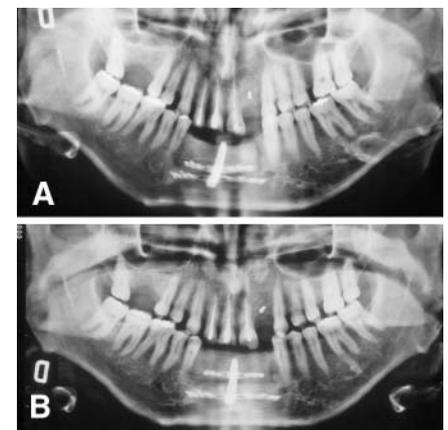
Orthopantomographs of the dentulous patient at the beginning (A), and at the end of the distraction period (B). Notice the increase in the alveolar ridge.
